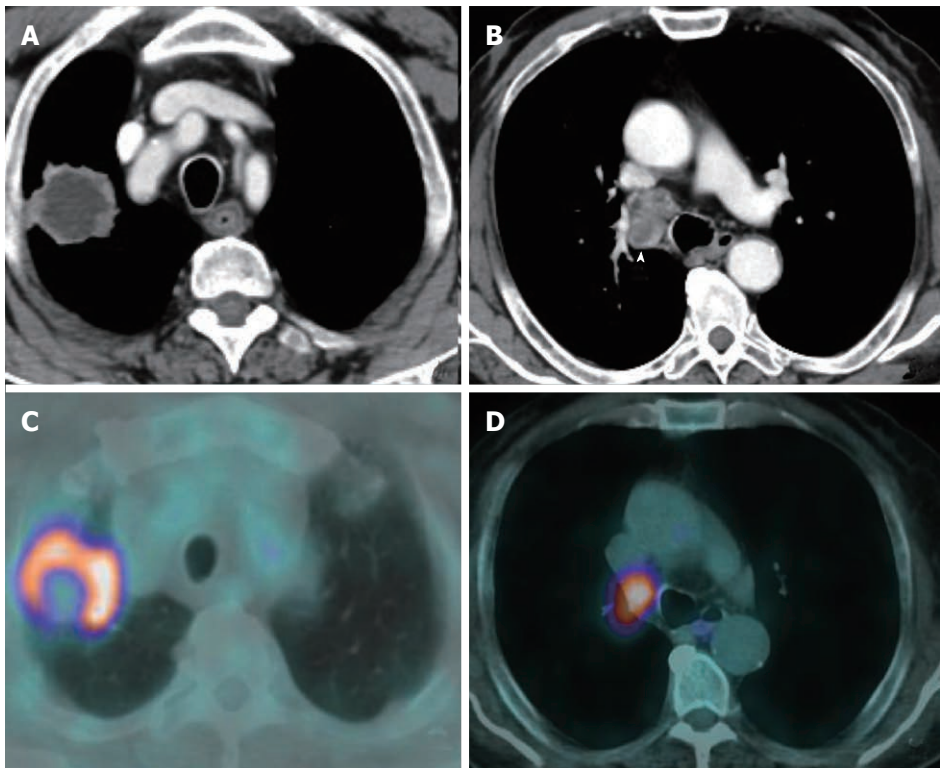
Contrast enhanced computed tomography of the chest viewed with mediastinal window settings demonstrated a large necrotic mass in the right upper lobe (A) with enlarged necrotic paratracheal lymph nodes in station 4R (arrowhead) (B). C, D: Positron emission tomography-computed tomography demonstrated high [18F]-2-fluoro-2-deoxy-d-glucose uptake in the mass and lymph nodes confirming a T2aN2 lung cancer.
